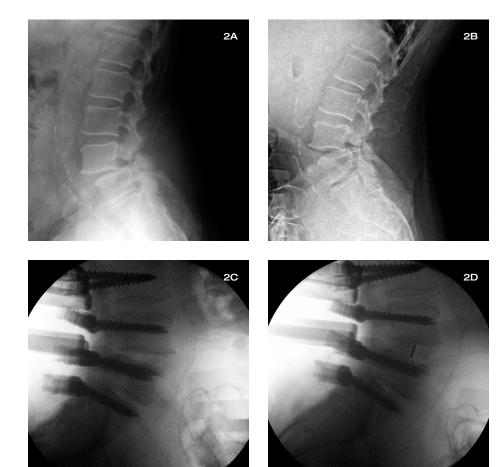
Weight-bearing lateral X-ray demonstrating an iatrogenic pars defect and spondylolisthesis.
